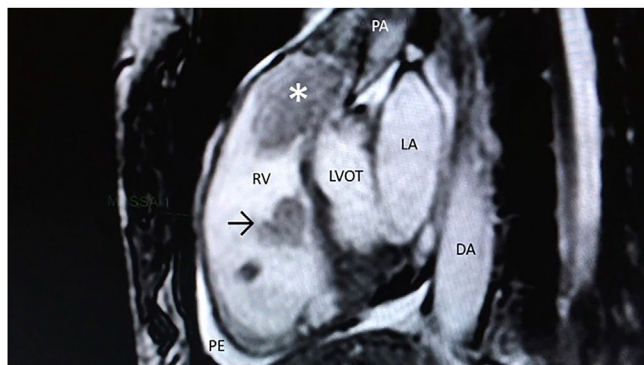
Cardiac magnetic resonance imaging showing a large mass (*) and a smaller one (arrow) inside the RV. DA: descending aorta; LA: left atrium; LVOT: left ventricle outflow tract; PA: pulmonary artery; PE: pericardial effusion; RV: right ventricle.
